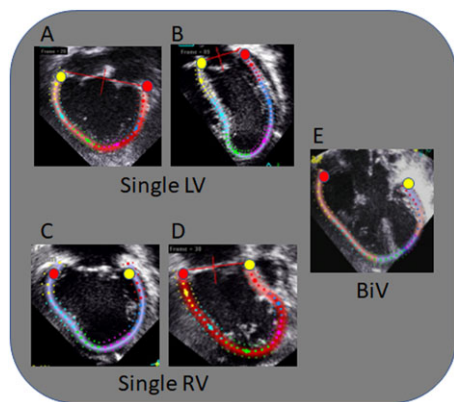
Examples of strain tracking region of interest and tissue Doppler sampling location for the various single ventricular morphologies represented in this study. The red dot shows the prescribed tissue Doppler imaging sampling location of the dominant ventricular annulus, and the yellow locates the other sampling location (septal versus non-dominant ventricle). Single LV: A) with no substantial RV mass and B) with a hypoplastic RV and no ventricular septal defect. Single RV: C) with no substantial LV mass and D) with a hypoplastic LV, no ventricular septal defect, and no outflow. Biventricular anatomy: E) with a right dominant unbalanced atrioventricular septal defect.
